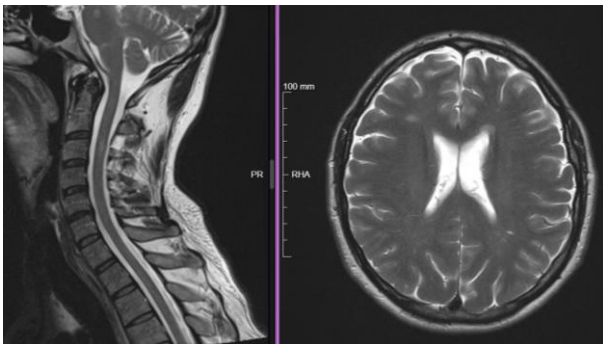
MRI revealing brain and cervical spinal cord lesions.
